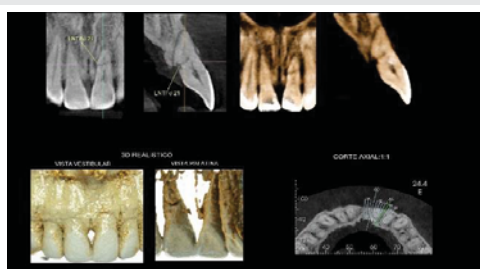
CBCT image showing root fracture of tooth 21.
